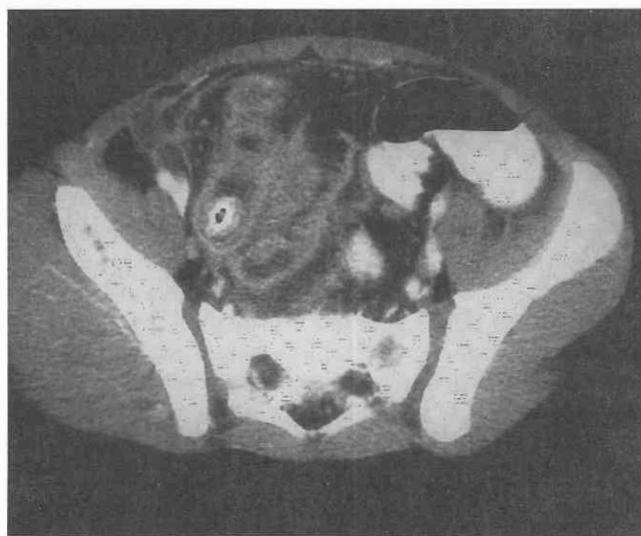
Appendicolith. CT scan through the upper pelvis of a patient with appendicitis shows an enlarged appendix containing an appendicolith.
